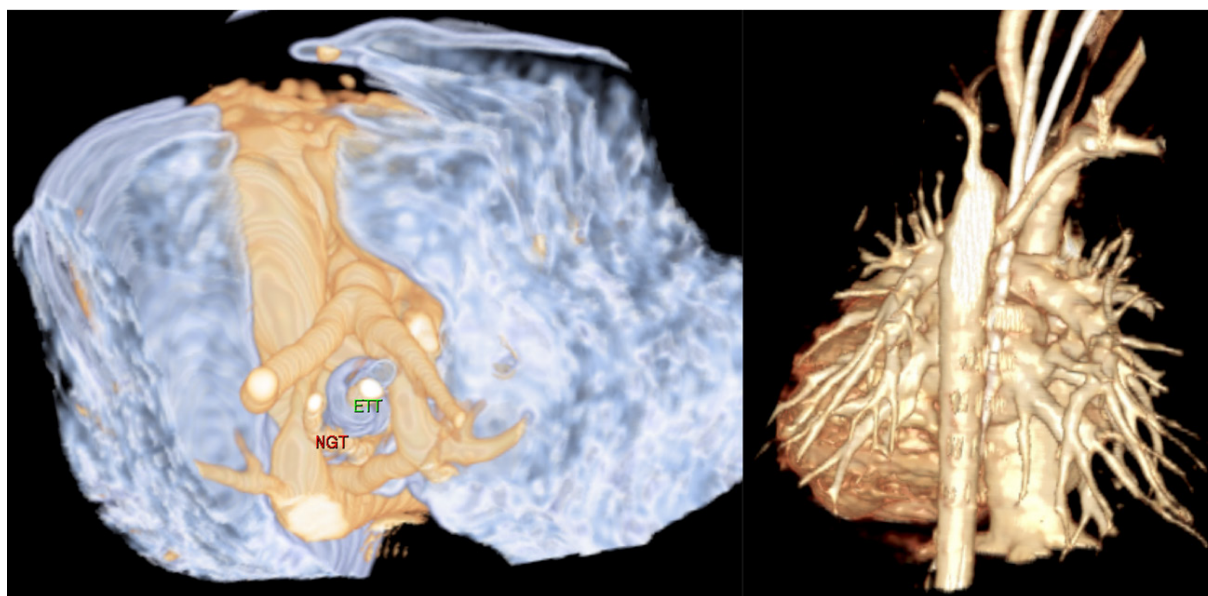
Computed tomography scan demonstrating (left) cross-section aerial view of a circumflex aorta with right aortic arch, encircling the airway [endotracheal tube (ETT)] and oesophagus [nasogastric tube (NGT)]; and (right) posterior view of the same patient demonstrating the hypoplastic retroesophageal aortic arch segment
